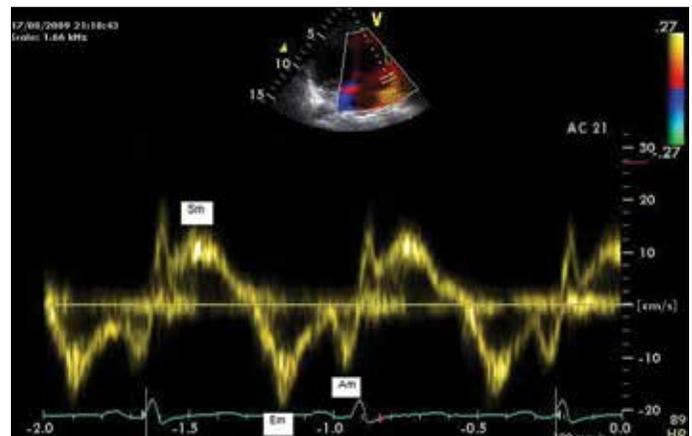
Tissue Doppler imaging of the right ventricular lateral wall tricuspid annulus in a patient with nasal polyposis
